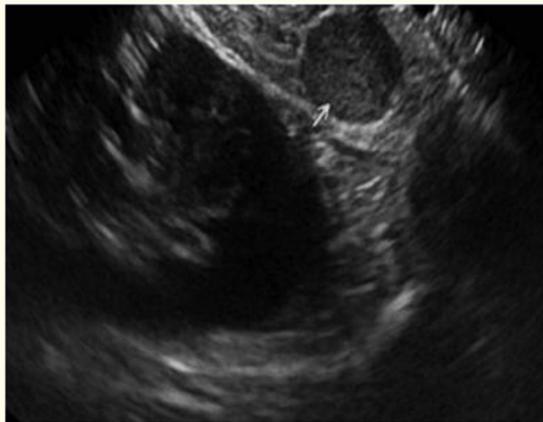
EUS image showed a small homogeneous hypoechoic lesion in pancreas tail on endoscopic ultrasound.
